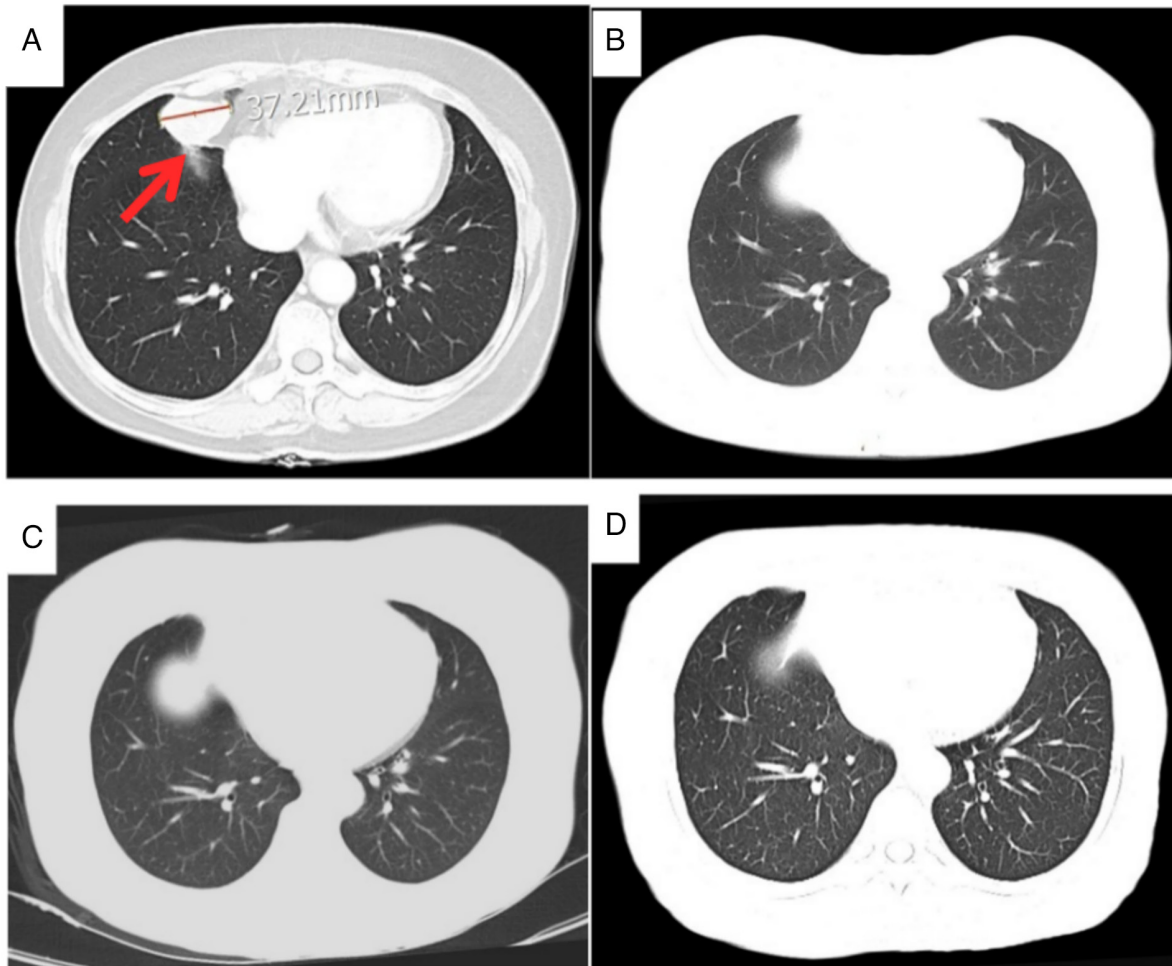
Chest CT images of the pulmonary lymphoepithelioma-like carcinoma patient. (A) Preoperative in November 2021 (lesion measuring 37.21 mm, arrow). (B) Before the first chemotherapy after surgery in January 2022 (the lesion is not visible). (C) After the first chemotherapy session after surgery in March 2022 (no obvious recurrence or metastasis). (D) In February 2025 (no obvious recurrence or metastasis).
